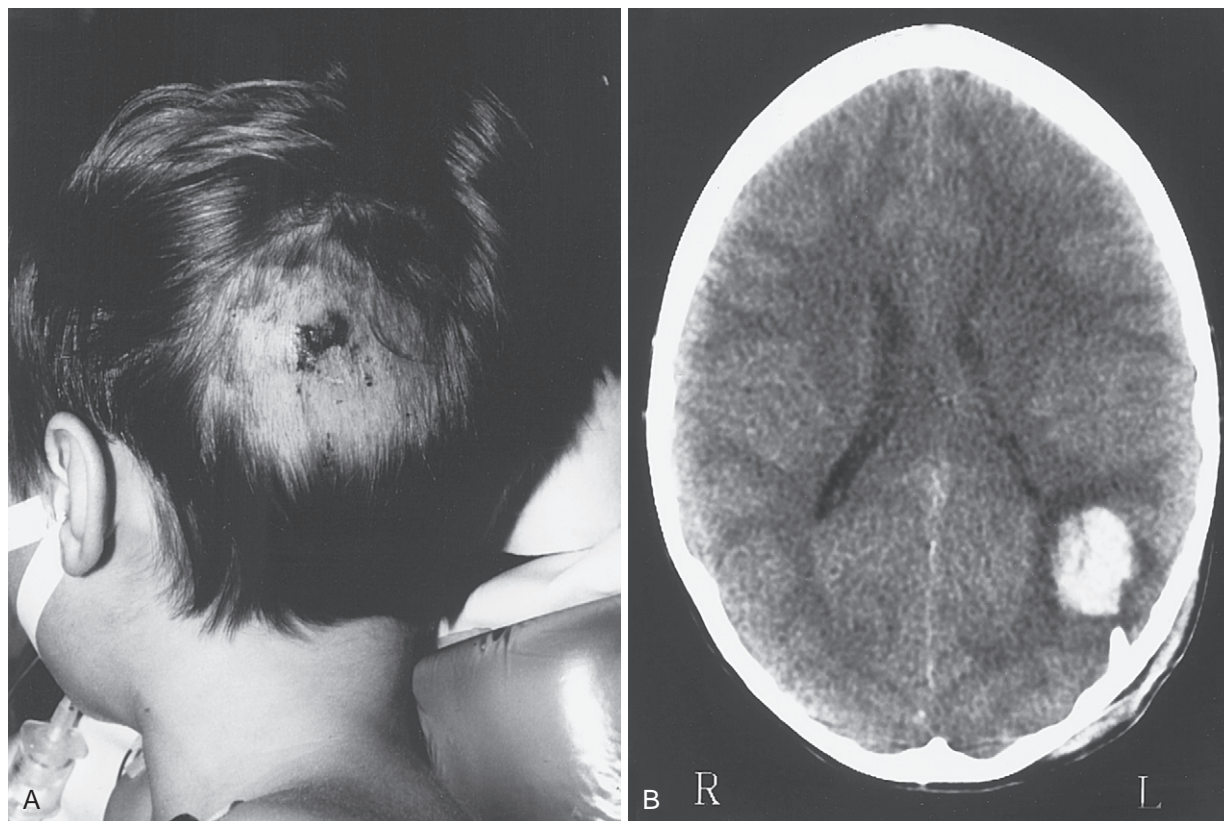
The occult injury frequently seen with low-velocity cranial penetration in young children is demonstrated. The patient was struck in the left parietal region by a lawn dart, and loss of consciousness did not occur. The lawn dart fell out immediately. The injury was misinterpreted as a minor scalp laceration and was closed with butterfly bandages. Three days later, fever and headache developed. A, Appearance of the entry wound before surgical exploration. B, Computed tomography shows a compound fracture and intracerebral hematoma. During surgery, hair, dirt, and bone fragments were removed from the cerebral cortex.
